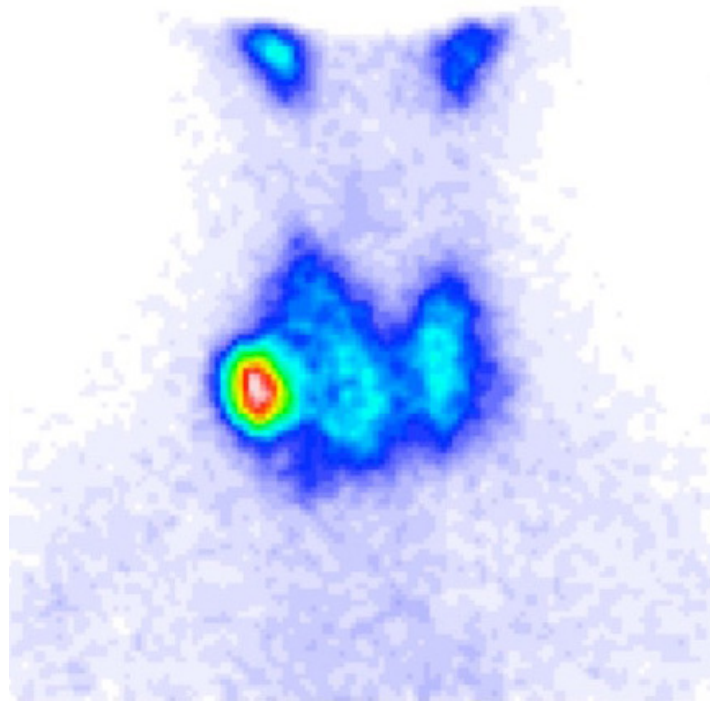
Clinical scintigram of a thyroid patient. Note the shape of the neck and the chest, and particularly the hotspot at the thyroid. (*Courtesy of Klinikum Rechts der Isar, Nuklearmedizin.*)
